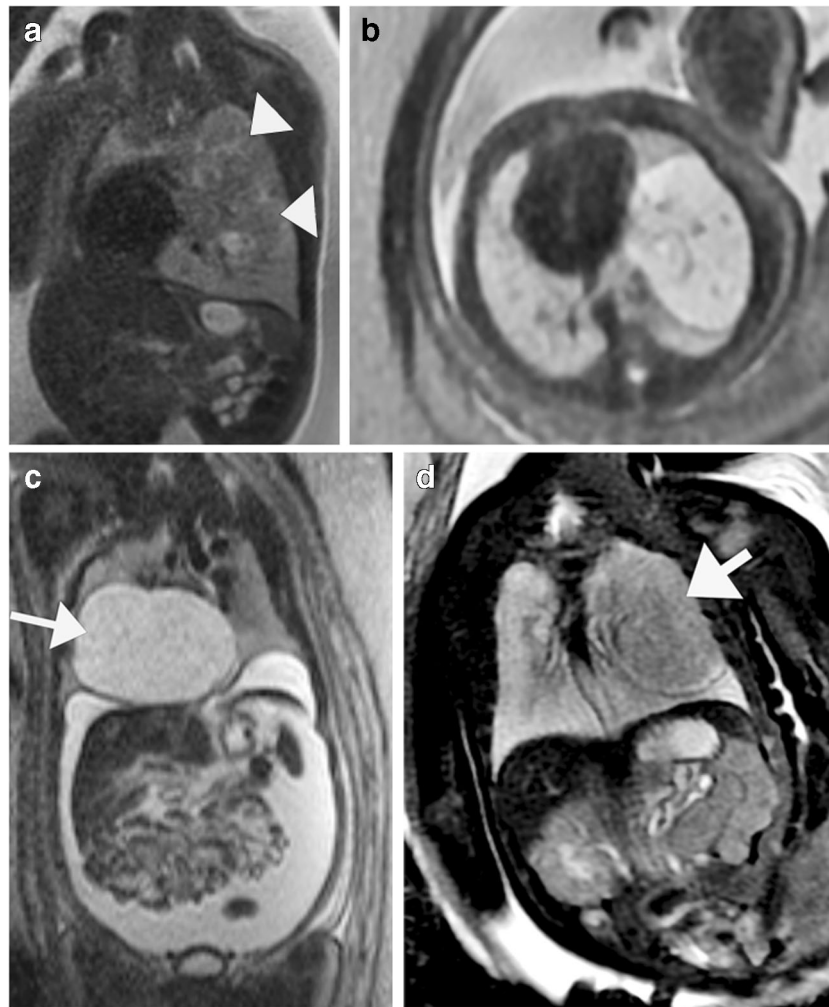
Primary pulmonary tumors. a Congenital peribronchial myofibroblastic tumor (CPMT). Coronal single-shot turbo spin-echo (SSTSE) MR image in a 33-week fetus with a large mass (*arrowheads*) demonstrates predominantly T2-hypointense components, mixed with smaller cysts. On postnatal pathology the mass represented CPMT. b Pleuropulmonary blastoma (PPB). Axial SSTSE MR image shows a T2-hyperintense, well-marginated mass with no significant mass effect seen in the third-trimester (image courtesy of Beth Kline-Fath, MD). Note how PPB can be difficult to distinguish from a congenital pulmonary
